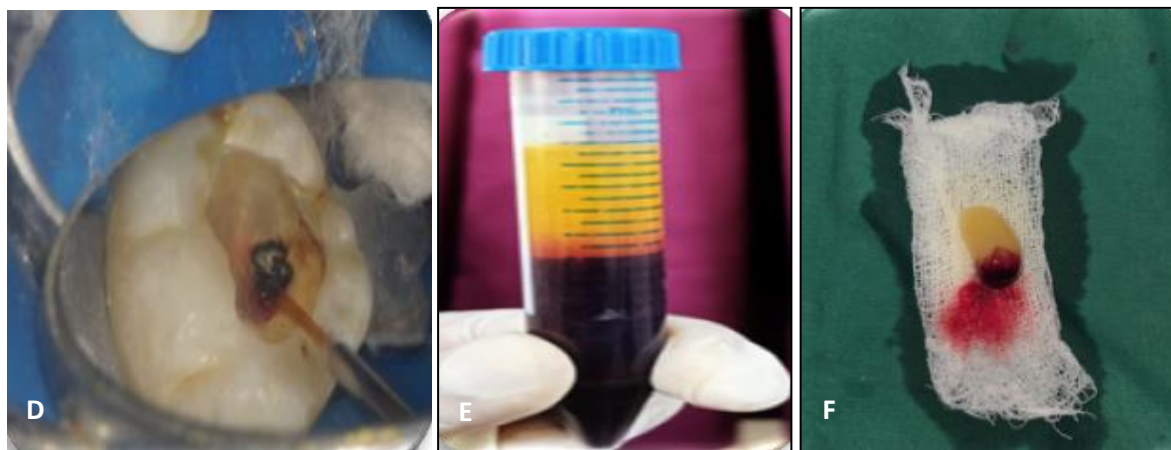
(a) Pre, operative clinical picture (b)Pre, operative radiograph (c)Pulp exposure (d)Haemostasis using diode laser (e), (f) A-PRF+
